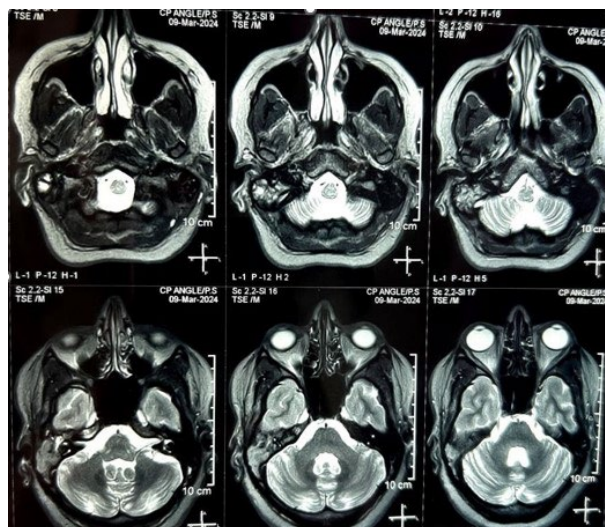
Axial section of T2 weighted MRI of temporal bone shows hyper intense lesion in the right temporal bone.
